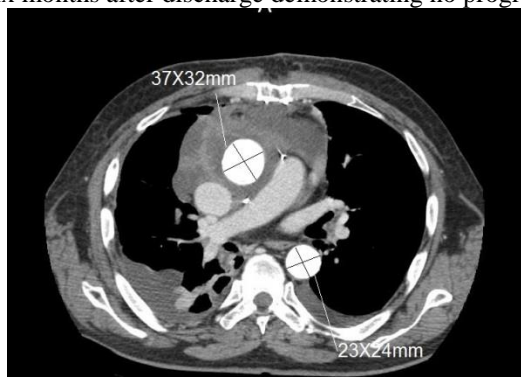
CT-scan performed one year after discharge demonstrating no progression in the diameter of the aorta.
